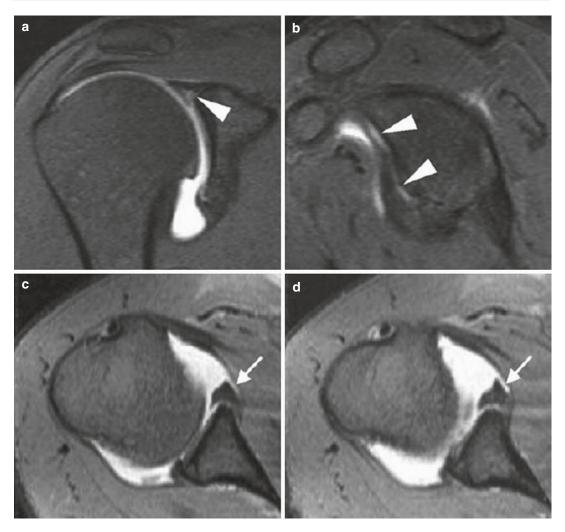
SLAP type II lesion in association with a Bankart lesion in traumatic anterior glenohumeral instability. (a) Coronal oblique fat-suppressed T1-weighted MR arthrogram shows superior extension of contrast media into the superior labrum and biceps anchor (*arrow*-*head*). (b) Corresponding sagittal oblique MR arthrogram
